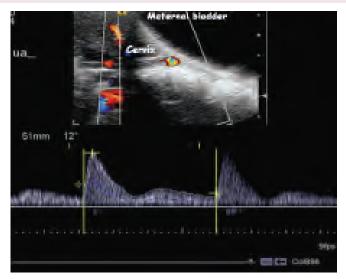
Evaluation of the uterine artery blood flow using Doppler
